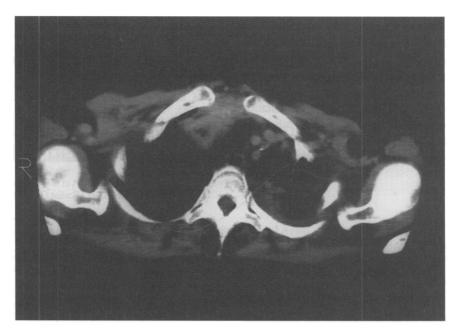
Post-treatment CT scan of thoracic inlet demonstrates resolution of the esophageal thickening and more severe left-lung fibrosis. The irradiated volume was symmetrical and the left pulmonary fibrosis is consistent with this site receiving prior irradiation.
